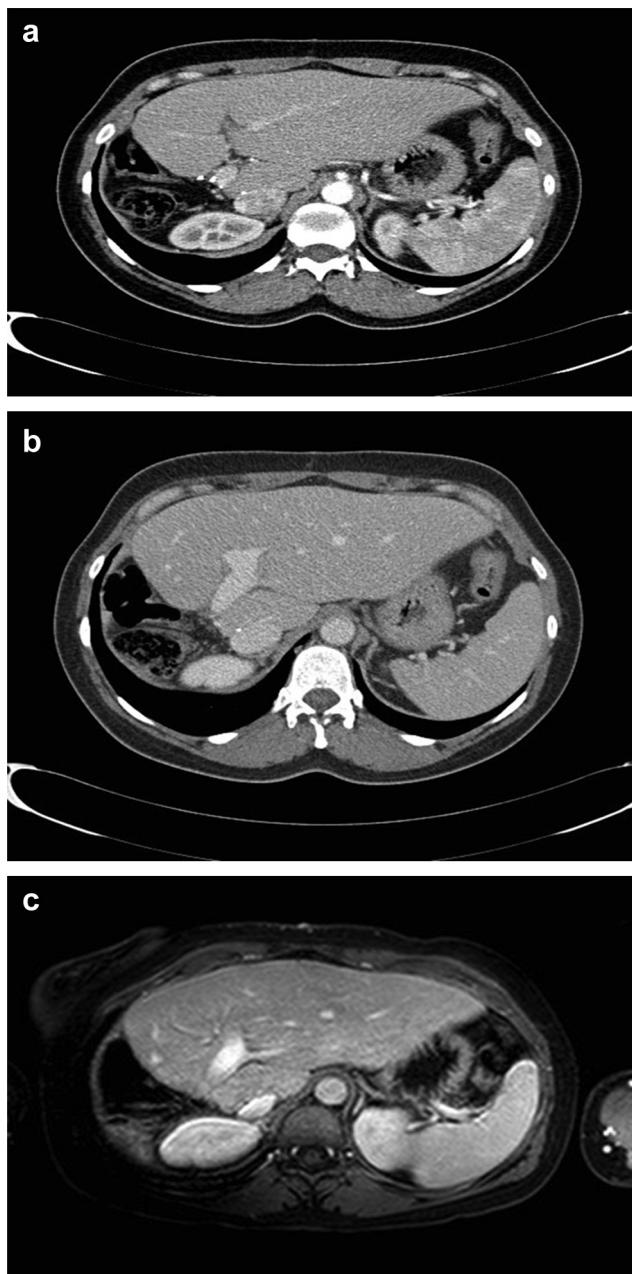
(a), (b), and (c) represent CT arterial phase, CT portal venous phase, and contrast-enhanced MRI T1 sequence (Portal Venous phase), respectively.
